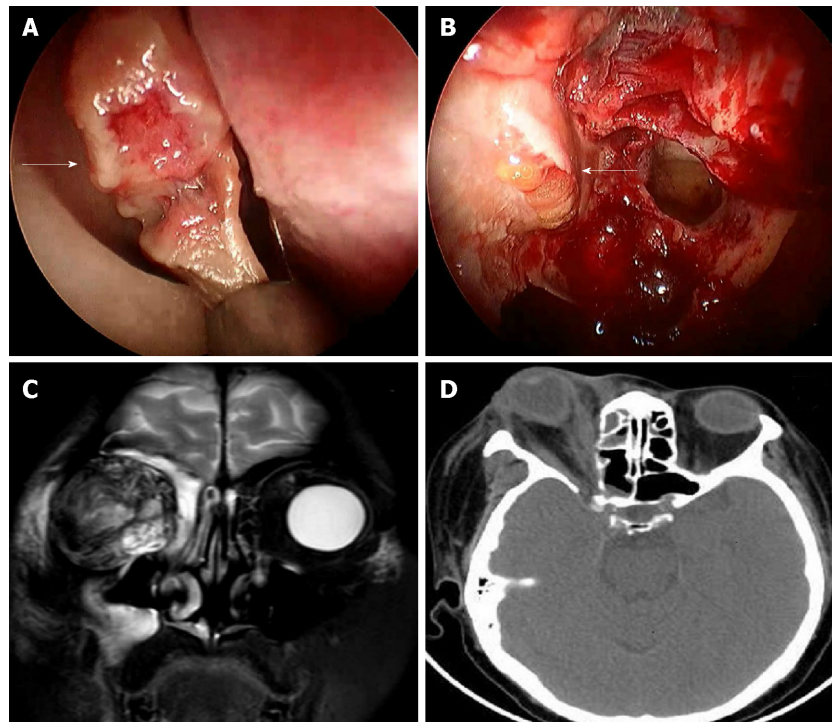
Nasal endoscopy, computed tomography, and magnetic resonance imaging images. A: Endoscopic sinus surgery showed that the middle turbinate turned to be necrotic and fragile; B: The orbital fat appeared dark yellow, losing its bright color; C: Magnetic resonance imaging T2-weighted coronal image; D: Axial computed tomography scan with soft tissue window revealed inflammatory changes in the orbital fat, right ocular proptosis, thickening of extraocular muscles, and the distorted eyeball.
